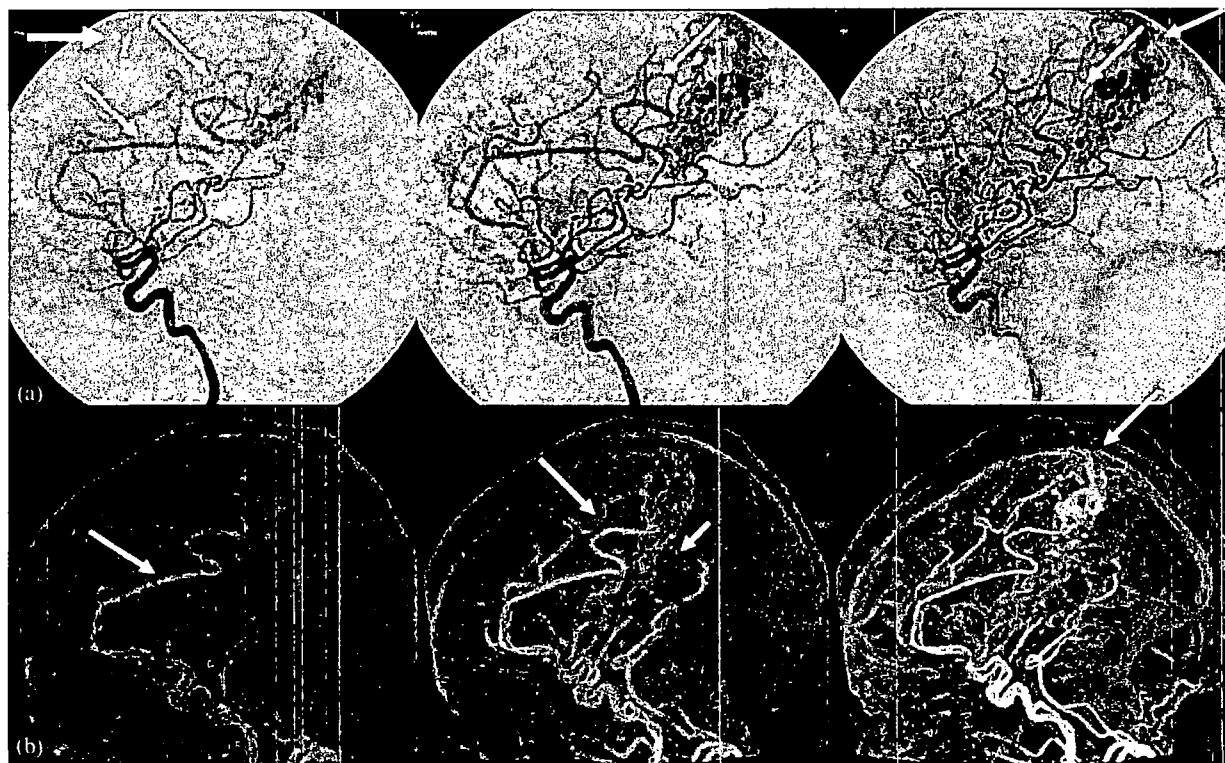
Sagittal whole-brain maximum intensity projection 4D CTA series (b) compared with a sagittal digital subtraction angiography projection (a) in a patient with acute intracerebral haemorrhage. An abnormally strong right pericallosal and callosomarginal artery are depicted feeding an aneurysmal nidus of a superficially draining arteriovenous malformation (arrows). On the second arterial image, a faint cortical venous contrast can be seen that becomes more pronounced at later time points (upper arrows in right column). As a consequence of the shunt, the draining cortical vein, as well as the superior sagittal sinus, are arterialised. The short arrow indicates smaller feeding branches of the right posterior cerebral artery. The thick arrow indicates the temporal axis.
